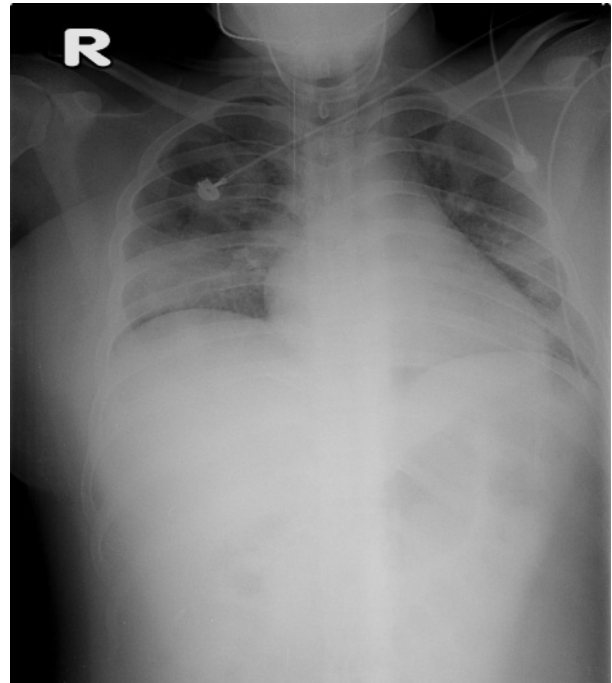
Frontal chest radiograph of a 20-year-old male, taken 4 days after symptom onset, showing a pleural-based consolidation over the right upper lung field.
